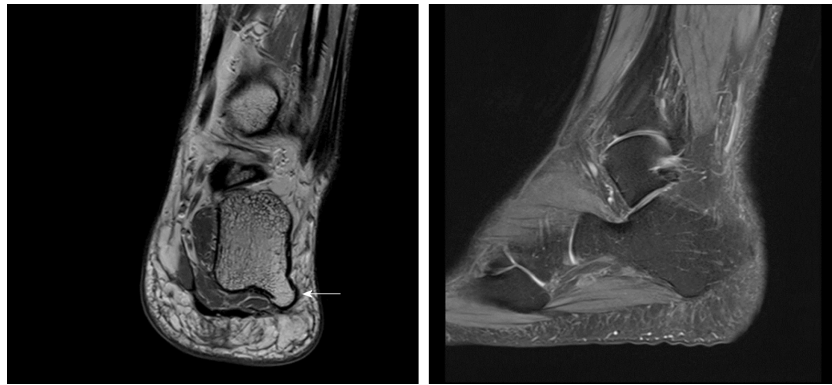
Magnetic resonance imaging of foot. A plantar osteochondroma arising from the posterolateral aspect of the calcaneus. No significant thickening in plantar fascia or signal alteration in the adjacent soft tissues or bone marrow to suggest recurrent plantar fasciitis
